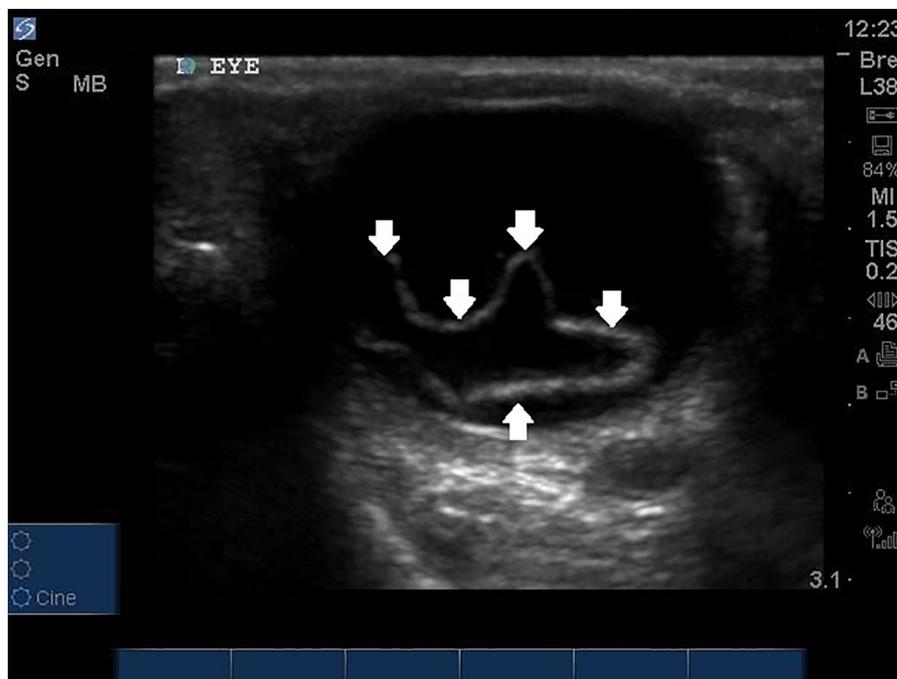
Still ultrasound image of cross-section of right eye, showing retinal detachment (arrows).
